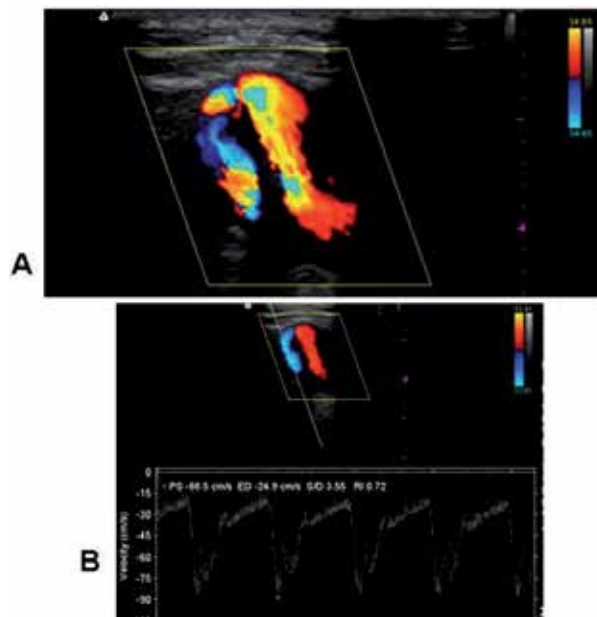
A: Color flow Doppler imaging discloses an internal carotid artery kinking. B: Color and pulsed-wave Doppler showed turbulences at the site of the kinking. However, both maximum systolic velocity and end-diastolic velocity of internal carotid arteries were substantially unaffected by kinking
